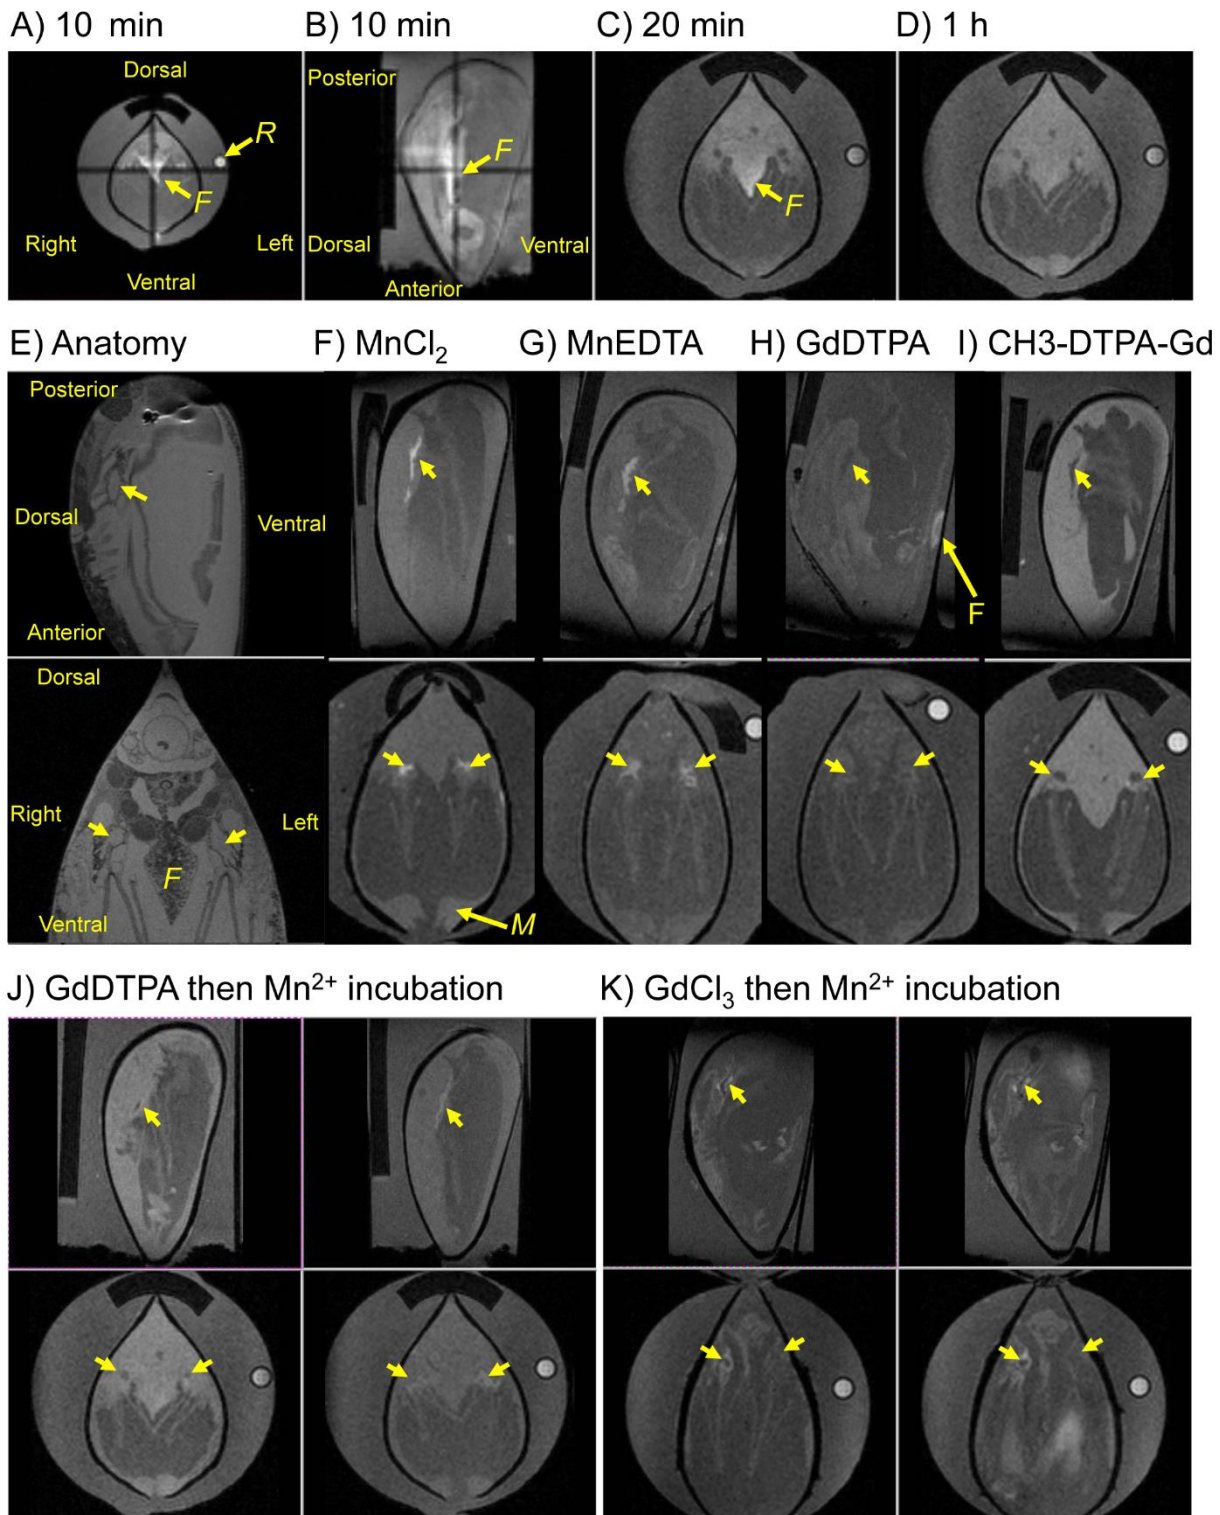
Distribution of injected MR tracers in *M. galloprovincialis* imaged by T_{1w} -MRI.
